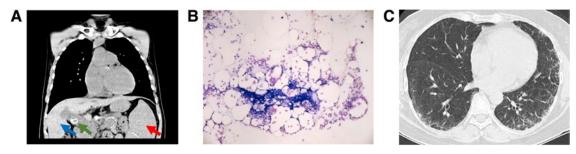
Clinical manifestations of telomere biology disorders in two adults. (A) Computed tomography scan (coronal plane) of a 35-year-old male with cryptogenic hepatic disease (case 1). Transjugular intrahepatic portosystemic shunt was set in place at the age of 21 years. Blue arrow indicates heterogenous liver parenchyma, green arrow transjugular intrahepatic portosystemic shunt, and red arrow splenomegaly. (B) Image of the hypocellular bone marrow biopsy of a 35-year-old TBD patient with severe cytopenia (case 1). (C) Pulmonary high-resolution computed tomography scan (axial plane) of a 54-year-old female with a TBD due to a heterozygous TERC mutation (case 2). Pulmonary bases bilaterally show peripheral interstitial and ground-glass opacities with early honeycombing. Findings are consistent with usual interstitial pneumonia pattern of pulmonary fibrosis. For all images written permission from patients was obtained. Figure 1C was previously published in Giri et al. 2019.¹²
